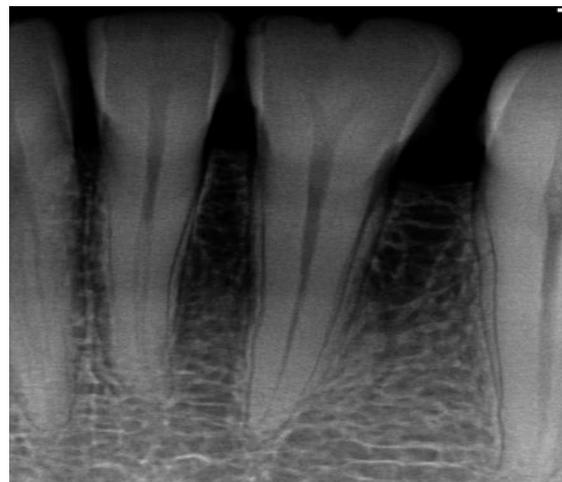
radiographic image
